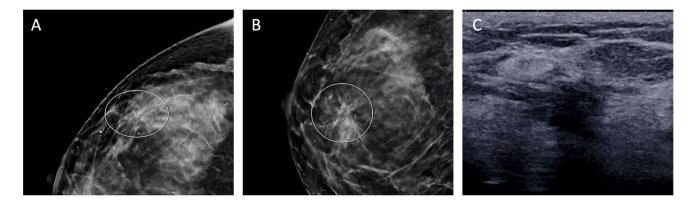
Architectural distortion with corresponding sonographic mass. Diagnostic mammogram spot CC (A) and ML (B) views showed architectural distortion (circle). A targeted ultrasound showed an
